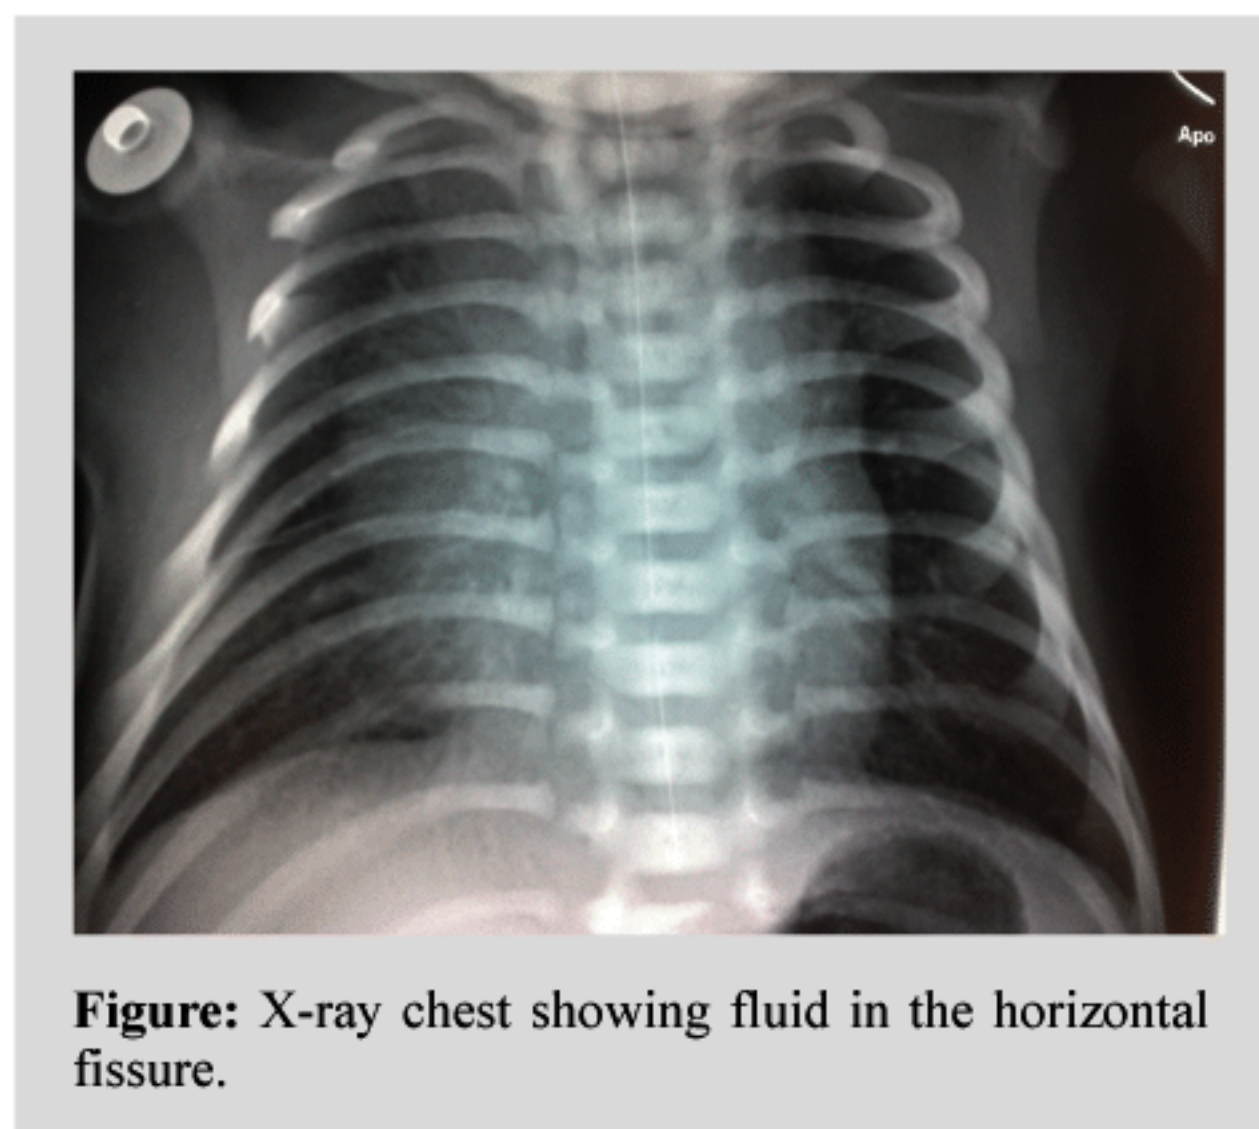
X-ray chest showing fluid in the horizontal fissure.
